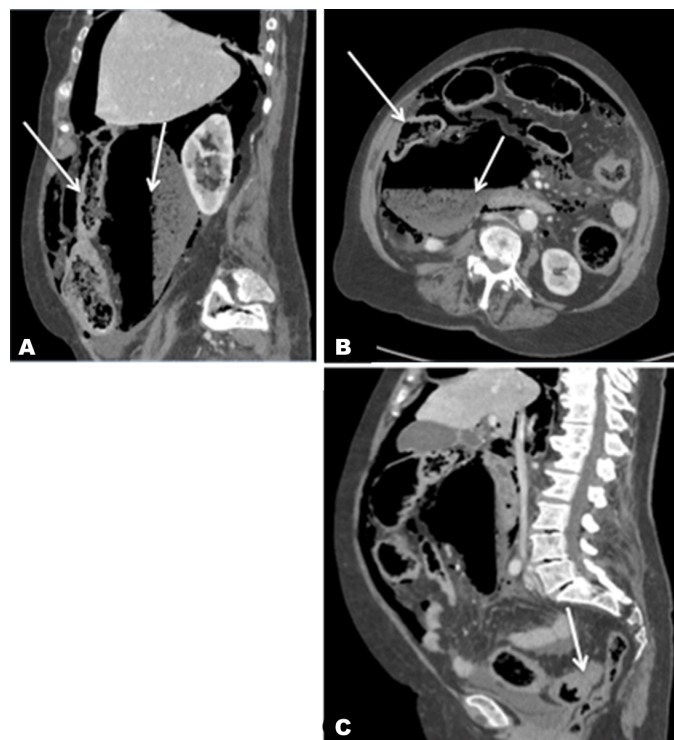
(A–C): Abdominal CT showed: (A, B) Pneumoperitoneum, the orifice of the right colon and the large abscess of 14x10x18 cm. Stenotic lesion of the sigmoid colon (C).
